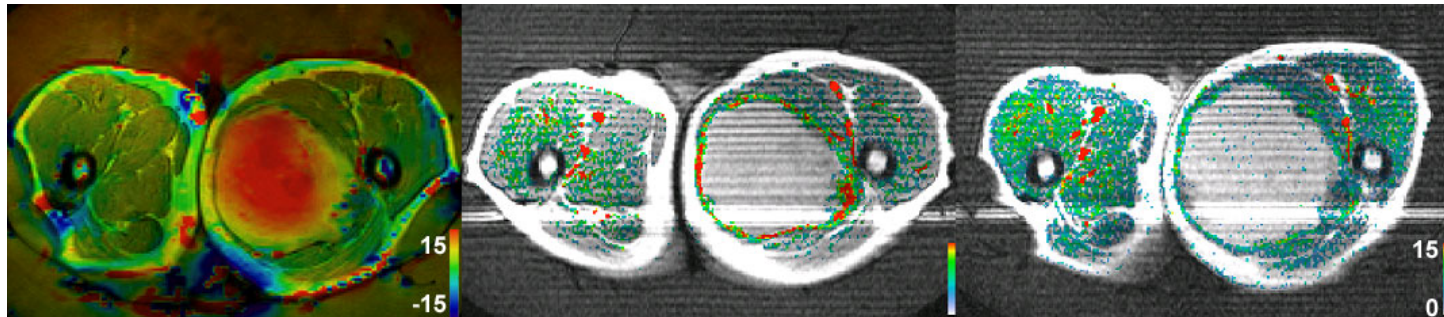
Map of temperature changes ΔT (scale in °C) in patient with soft tissue sarcoma in the left thigh just before power switch-off (left) and corresponding maps of perfusion (scale in ml/min/100ml) measured by DCE MRI basally before HT (mid) and just after power switch-off under the 1st HT fraction (right). Note the obvious perfusion reduction at tumor rim and perfusion increase in healthy muscle under RHT (vascular steal effect).
